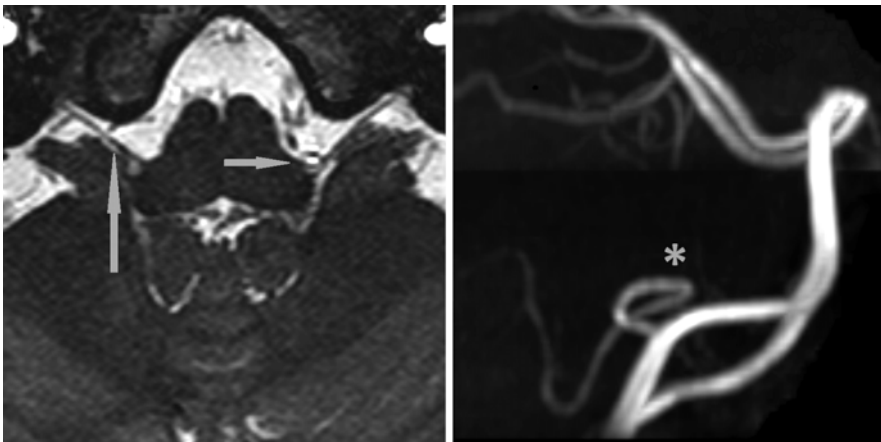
Magnetic resonance imaging of a patient with left-sided glossopharyngeal neuralgia. *Left panel:* An axial CISS imaging sequence through the medulla. The glossopharyngeal nerve (*vertical arrow*) courses from the postolivary sulcus, across the jugular tubercle, and enters
